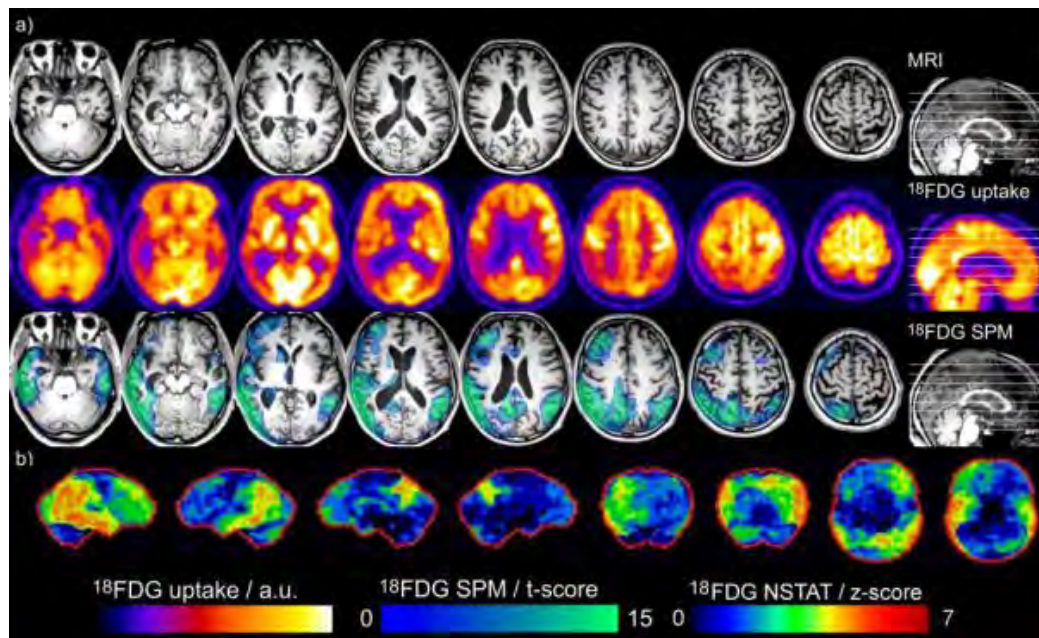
Combined T1-MRI, PET uptake and SPM maps (a) and NEUROSTAT projections (b) from a 57-year-old male with right temporal variant fronto-temporal dementia (case no. 23). Focal right medial temporal atrophy and more weakly dorsolateral prefrontal atrophy are observed. SPM PET maps highlight severe inferior-lateral temporal and parietal hypometabolism, with moderate changes also in right precuneus and cingulate cortex. The corresponding uptake maps and NEUROSTAT projections highlight similar changes but are less definitive in terms of localization of cingulate and frontal changes. Sections in (a) are shown in radiological convention (left side corresponds to right hemisphere), whereas NEUROSTAT projections (b) are shown in neurological convention (left side corresponds to left hemisphere).
